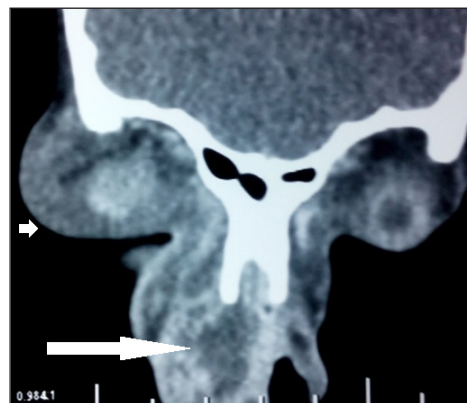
Coronal computed tomography scan showing the furuncle (lower arrow) and the preseptal cellulitis (upper arrow).
